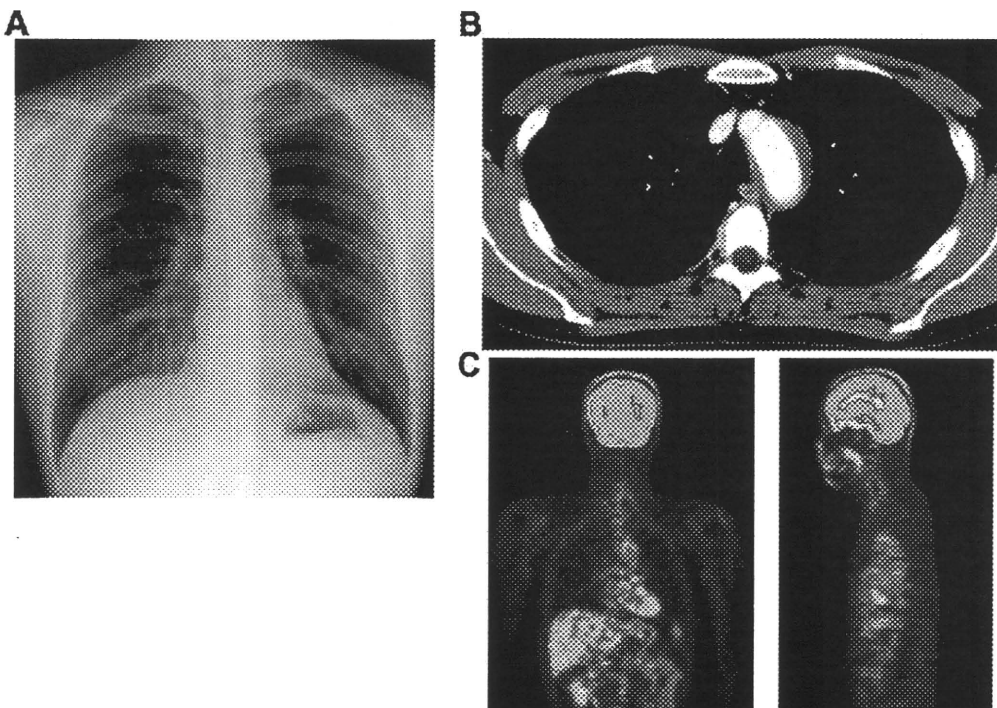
After the corticosteroid therapy, the chest radiograph (A) and CT scan (B) revealed a decrease in size of the periaortic mass. PET scanning (C) revealed no abnormal uptake of ^{18}F -FDG at the aortic arch.
